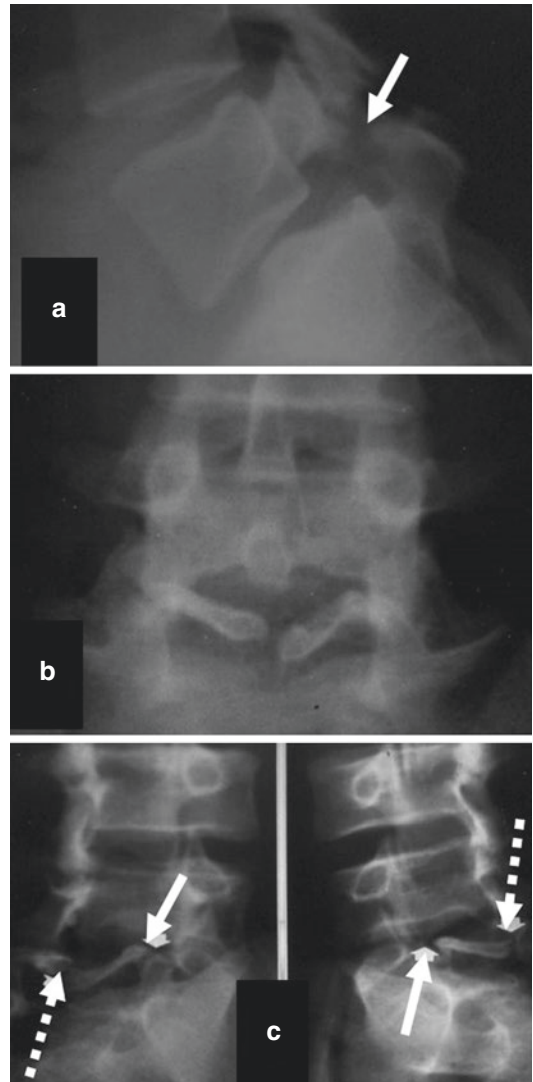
Radiographic study of the lumbar spine shows spondylolysis at L5 (arrows) in lumbosacral dysplasia. (a) Sagittal view shows trapezoidal spinal bone with sacral promontory in S italic. (b) Frontal view shows spina bifida occulta at L5 related to injury. (c) Bilateral oblique view shows “floating sheet” limited by spondylolysis and spina bifida occulta (discontinuous arrows)
